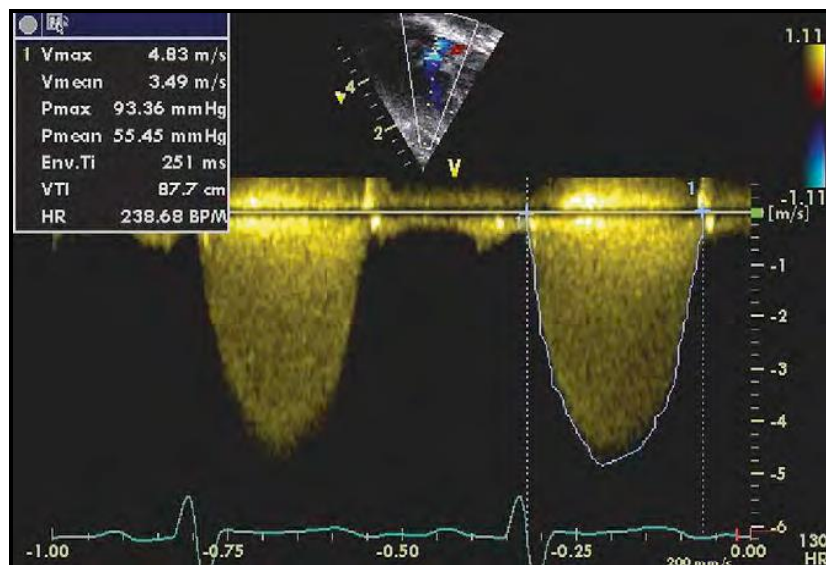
Continuous wave spectral Doppler across the pulmonary valve demonstrates a high velocity of flow, and calculated peak instantaneous and mean gradients across the valve.⁽²⁶⁾
